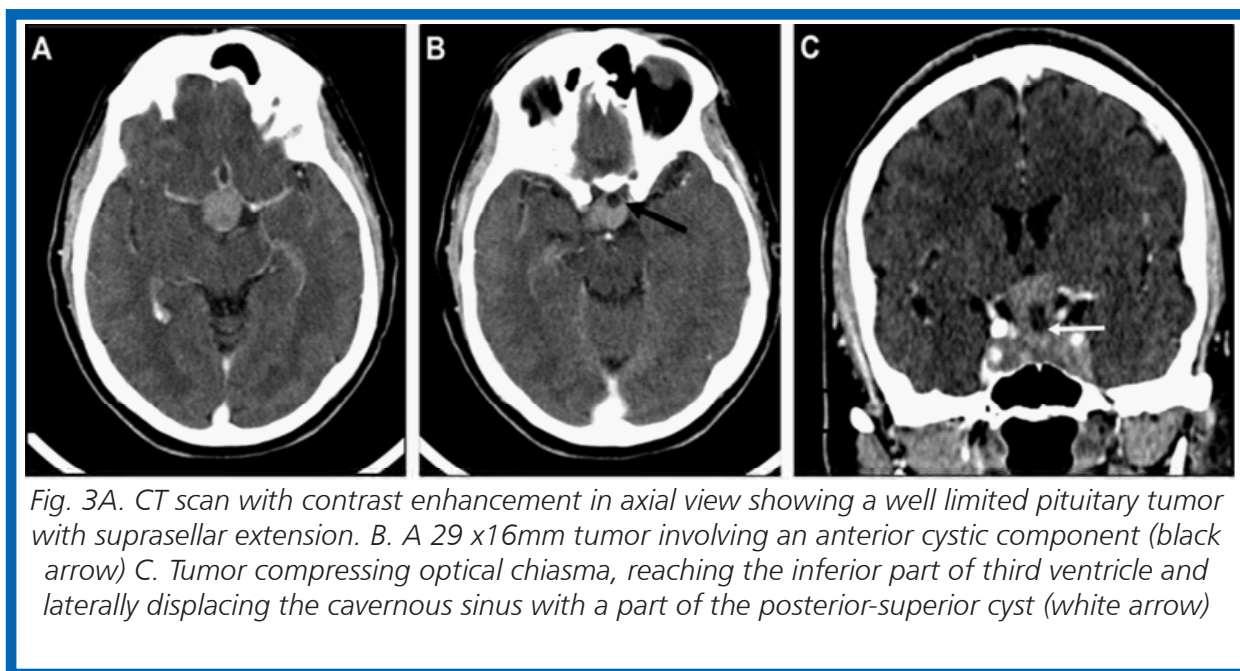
CT scan with contrast enhancement in axial view showing a well limited pituitary tumor with suprasellar extension. B. A 29 x16mm tumor involving an anterior cystic component (black arrow) C. Tumor compressing optical chiasma, reaching the inferior part of third ventricle and laterally displacing the cavernous sinus with a part of the posterior-superior cyst (white arrow)
